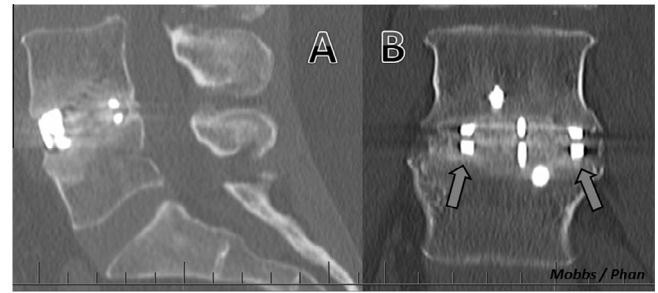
(A) Midsagittal and (B) coronal fine cut CT images at 12 months post L4/5 anterior lumbar interbody fusion demonstrating adjacent endplate sclerosis and the absence of radiolucency at the titanium-poly[aryl-ether-ether-ketone] (Ti-PEEK)-bone endplate interface (arrows).
